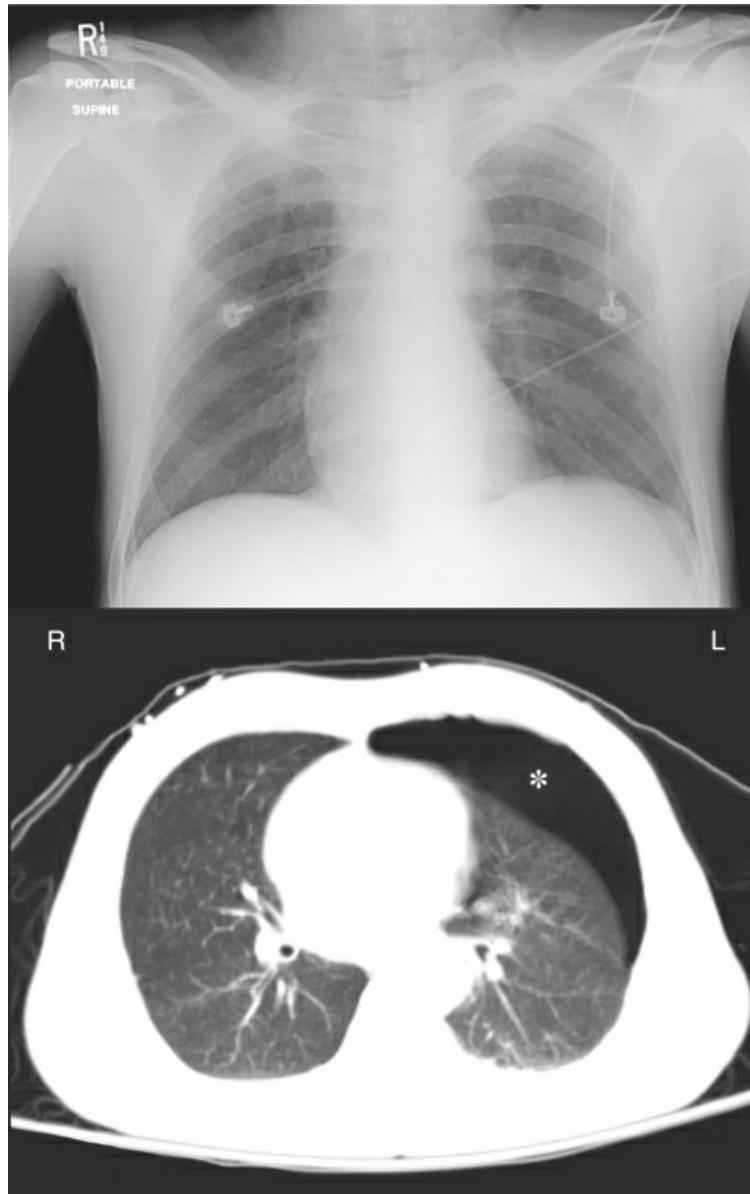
Portable chest x-ray and CT image of the chest in a young male with blunt chest trauma. The chest film is unrevealing, while the CT image shows an anterior pneumothorax (indicated by the asterisk).
